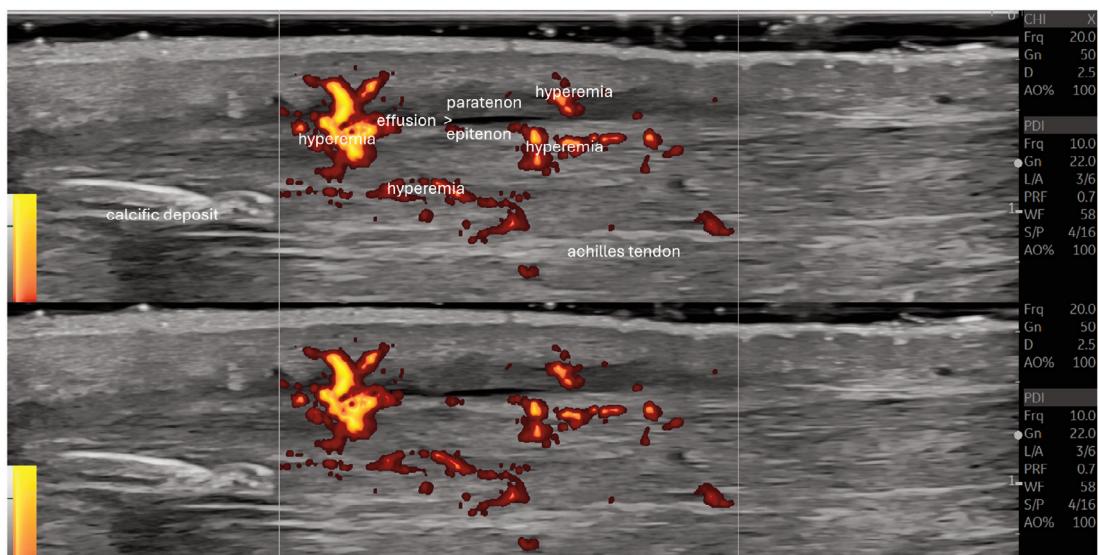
Longitudinal ultrasound images of the Achilles tendon in Power Doppler mode show hyperaemia of the Achilles tendon and of the paratenon. Furthermore, effusion in the paratenon lumen and calcific deposits are depicted.
